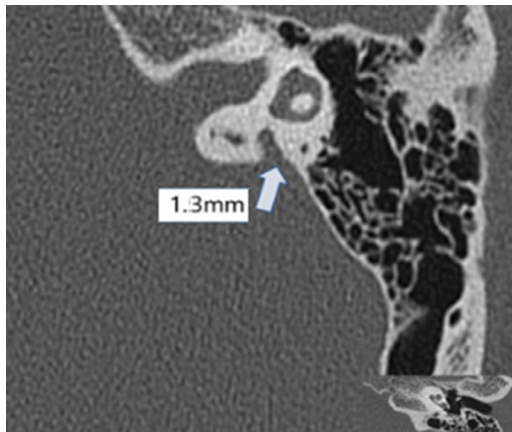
Temporal bone CT image of IV: 1. based on the criteria of diameter greater than 1.5 mm between the outer vestibular aqueduct and the vestibule of the total foot or the midpoint of the isthmus is abnormal.
